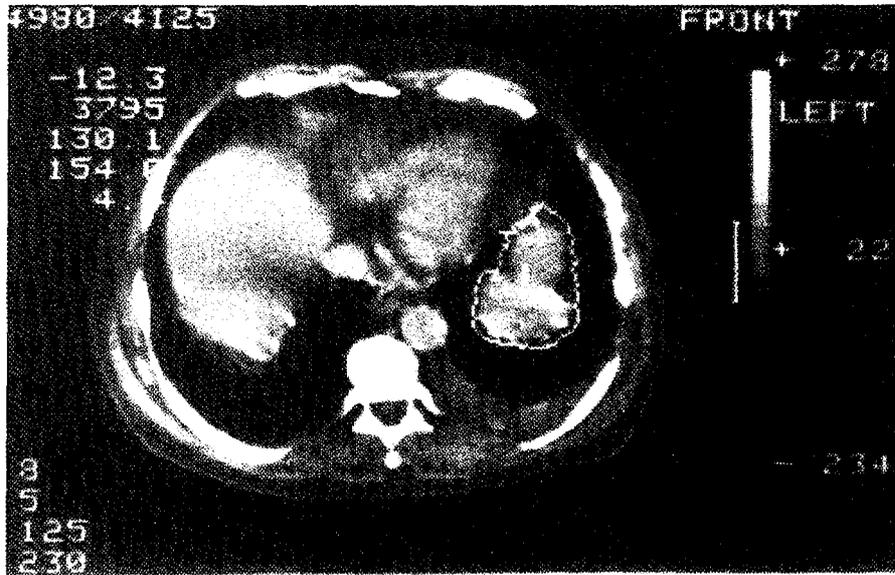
CT-scan of lung metastases after thyroid cancer: ROI placed over tumour on one slice, similarly relevant ROI's in other slices give tumour volume, when pixel size is known.
